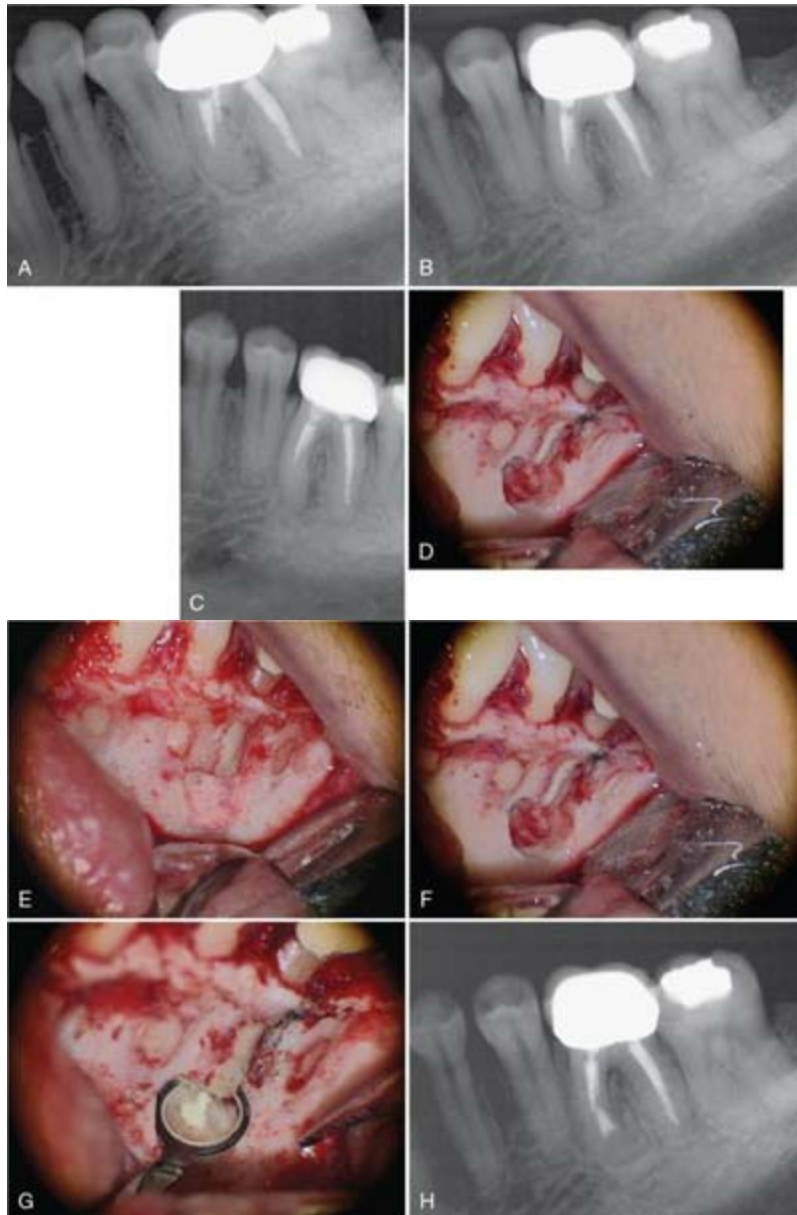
A, Preoperative radiograph (mesial angle) of a left mandibular first molar. Periradicular disease and symptoms had persisted after nonsurgical retreatment by an endodontic resident. The mesial canals were completely obstructed at the midroot level. The preoperative evaluation included three periapical radiographs, two different horizontal angulations, and one vertically positioned radiograph. B, Straight view preoperative radiograph. C, Vertical periapical view preoperative radiograph. D, Osteotomy and root resection perpendicular to the long axis of the root were performed; a partial bony dehiscence over the mesial root can be seen. E, Racellets were packed into the bony crypt to establish hemostasis. F, The Racellets were removed (one usually is left in the deepest part of the crypt during root-end preparation and filling), and the root end was
